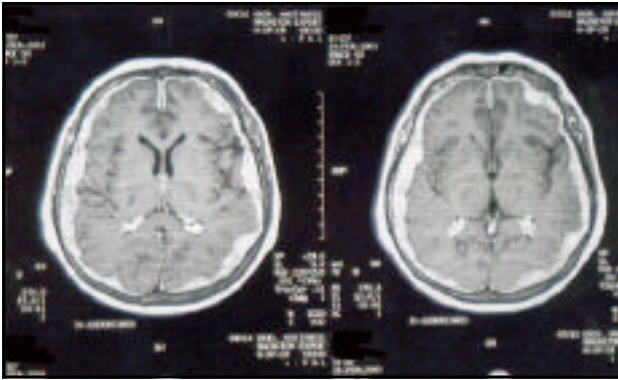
Cranial magnetic resonance imaging with intravenous gadolinium showing meningeal diffuse mass surrounding the brain.
